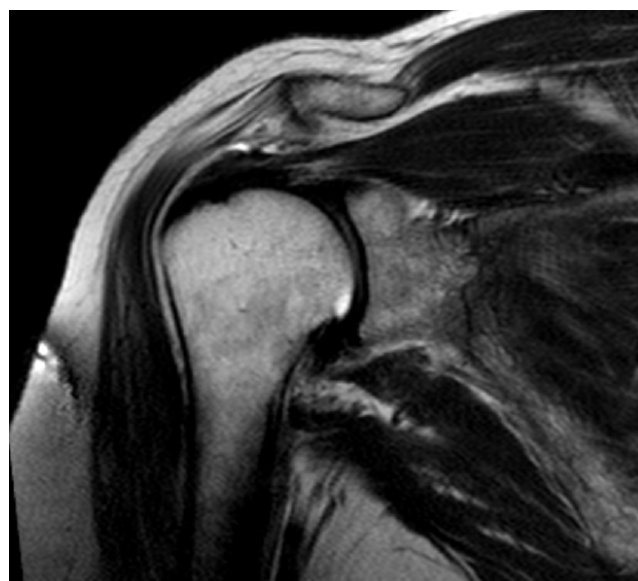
Magnetic resonance image of the infraspinatus.
